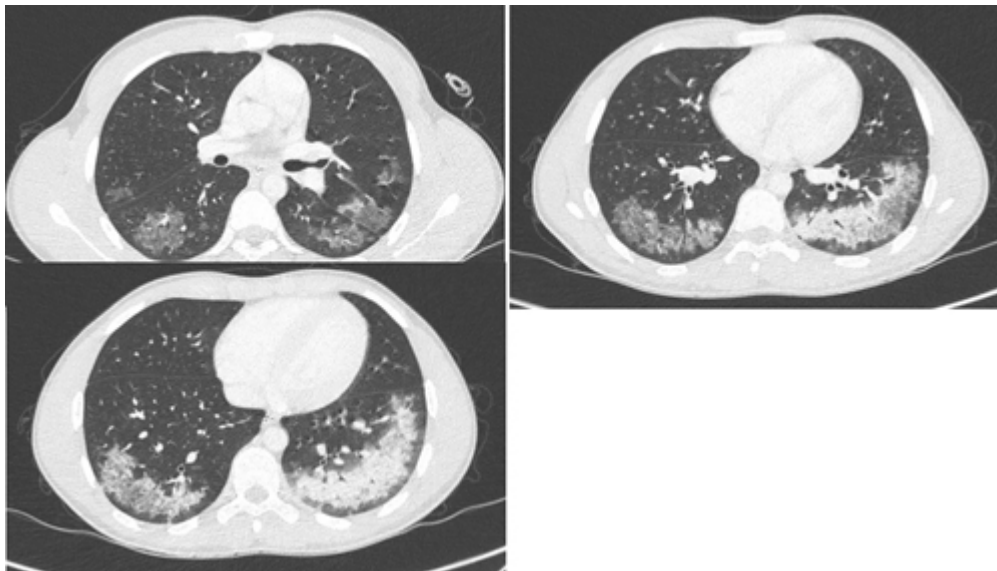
Initial CT scan performed at admission. [↩](#)
